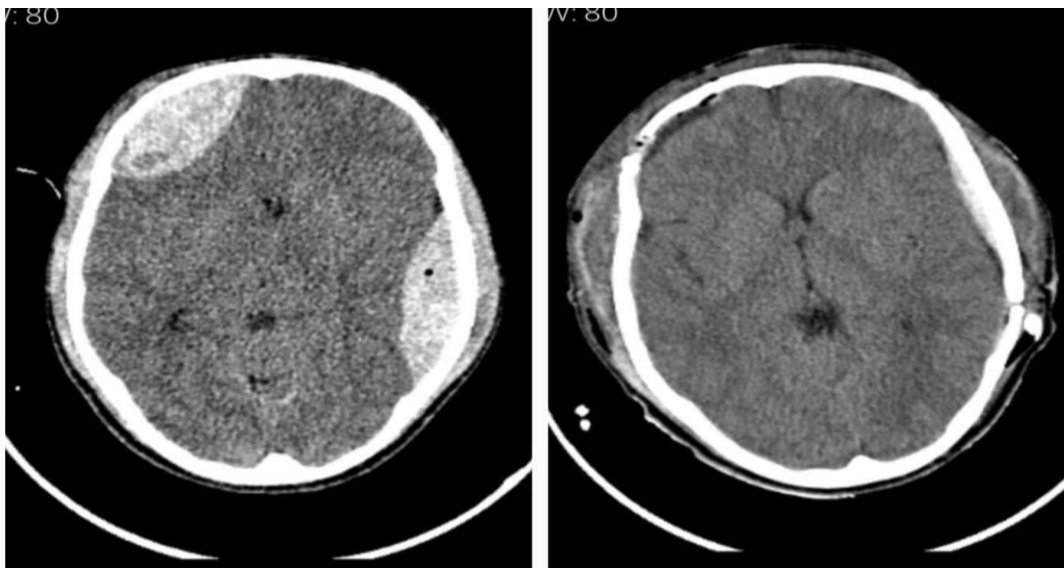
Axial CT Brain shows Frontal and Parietotemporal hematoma.
